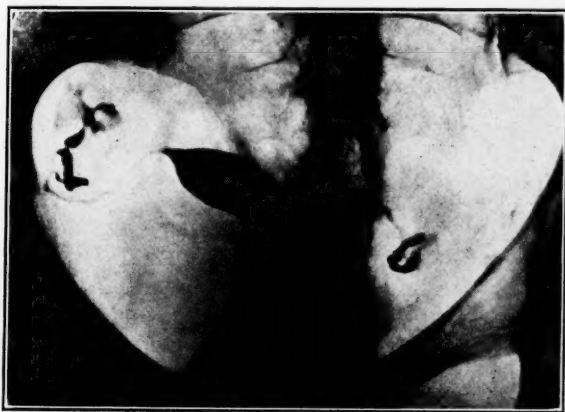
Lipiodol x-ray of bicornate uterus six weeks after removal of septum.
